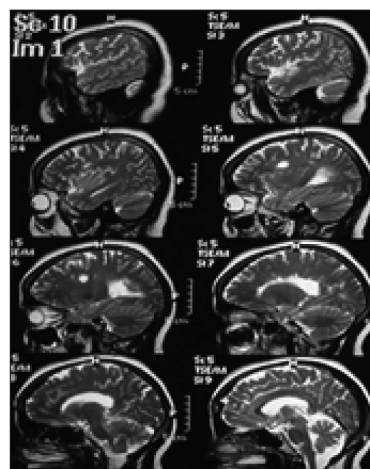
Brain magnetic resonance imaging (T2-weighted image) of multiple sclerosis patient
